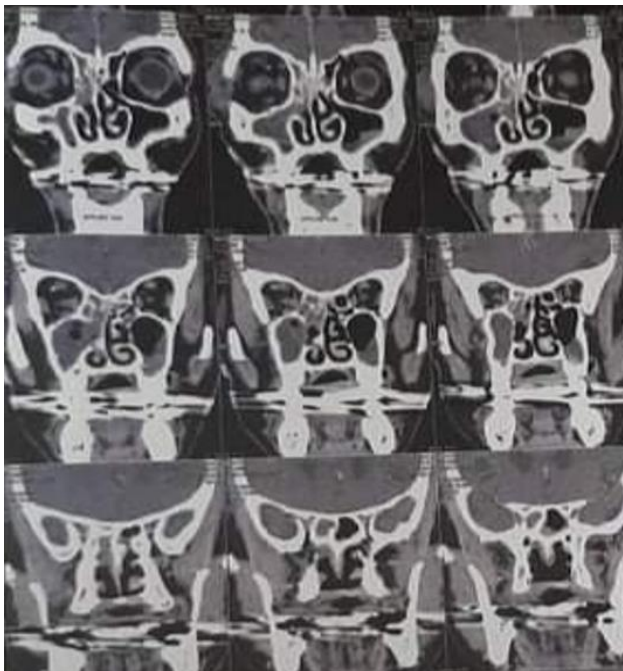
CT scan of the orbits & sinuses: a soft tissue swelling was noted in right preseptal regions with mild right proptosis
